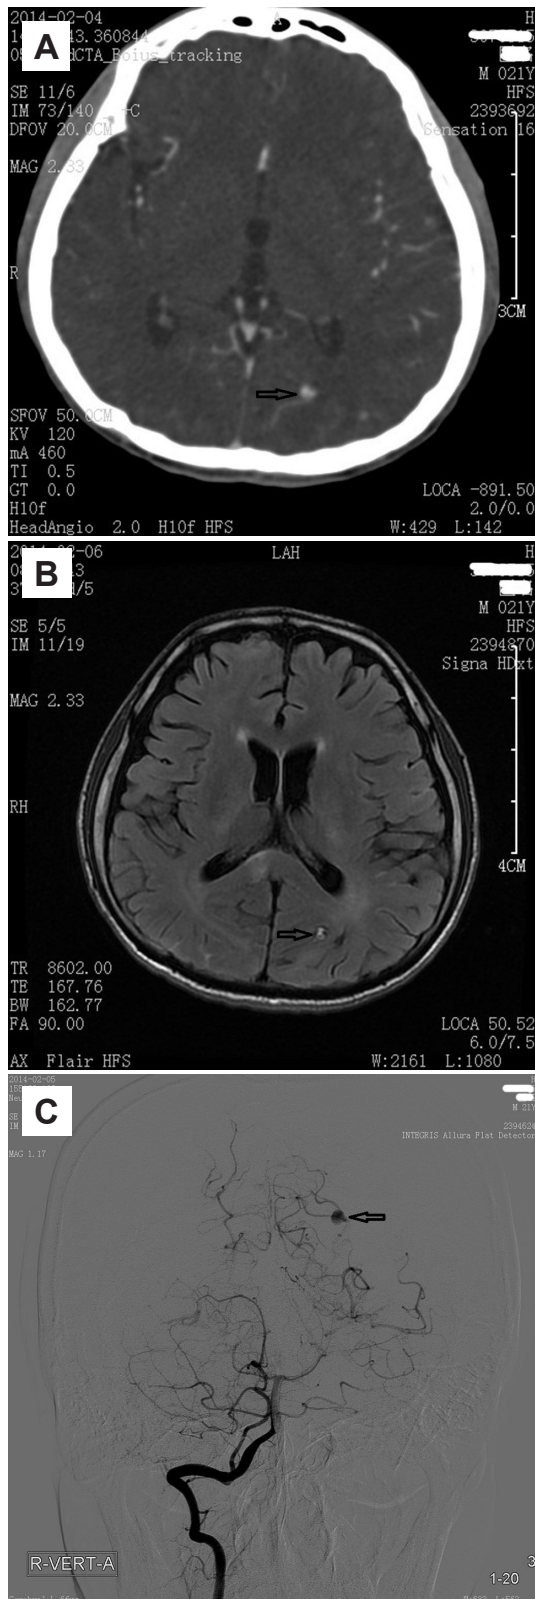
A, Cerebral CTA showed the mycotic aneurysm (MA) (arrow); B, Brain MRI showed the MA (arrow); C, Cerebral angiography showed the MA (arrow).
